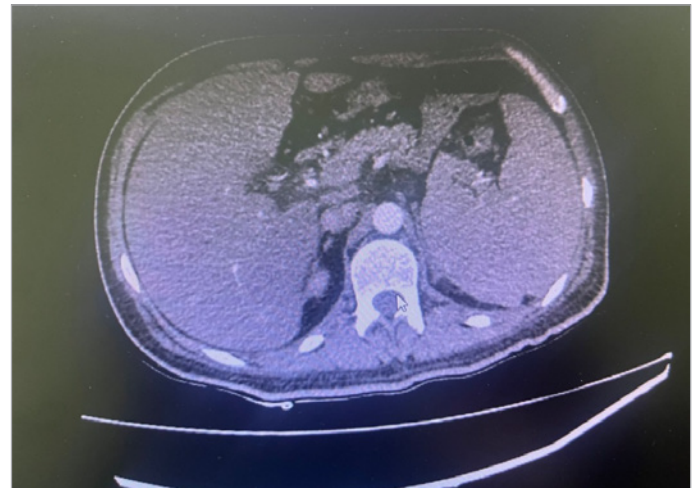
Abdominal CT 22/07/2022.
